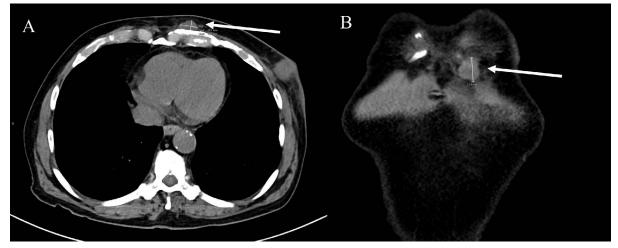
A 77-year-old male with primary metaplastic breast carcinoma with metastases to the lungs and chest wall. Findings: Non-contrast CT chest, abdomen and pelvis showed a well-circumscribed soft tissue nodule in the subcutaneous tissues of the left anterior chest wall. It measured 1.9 x 1.1 x 2.3 cm.
